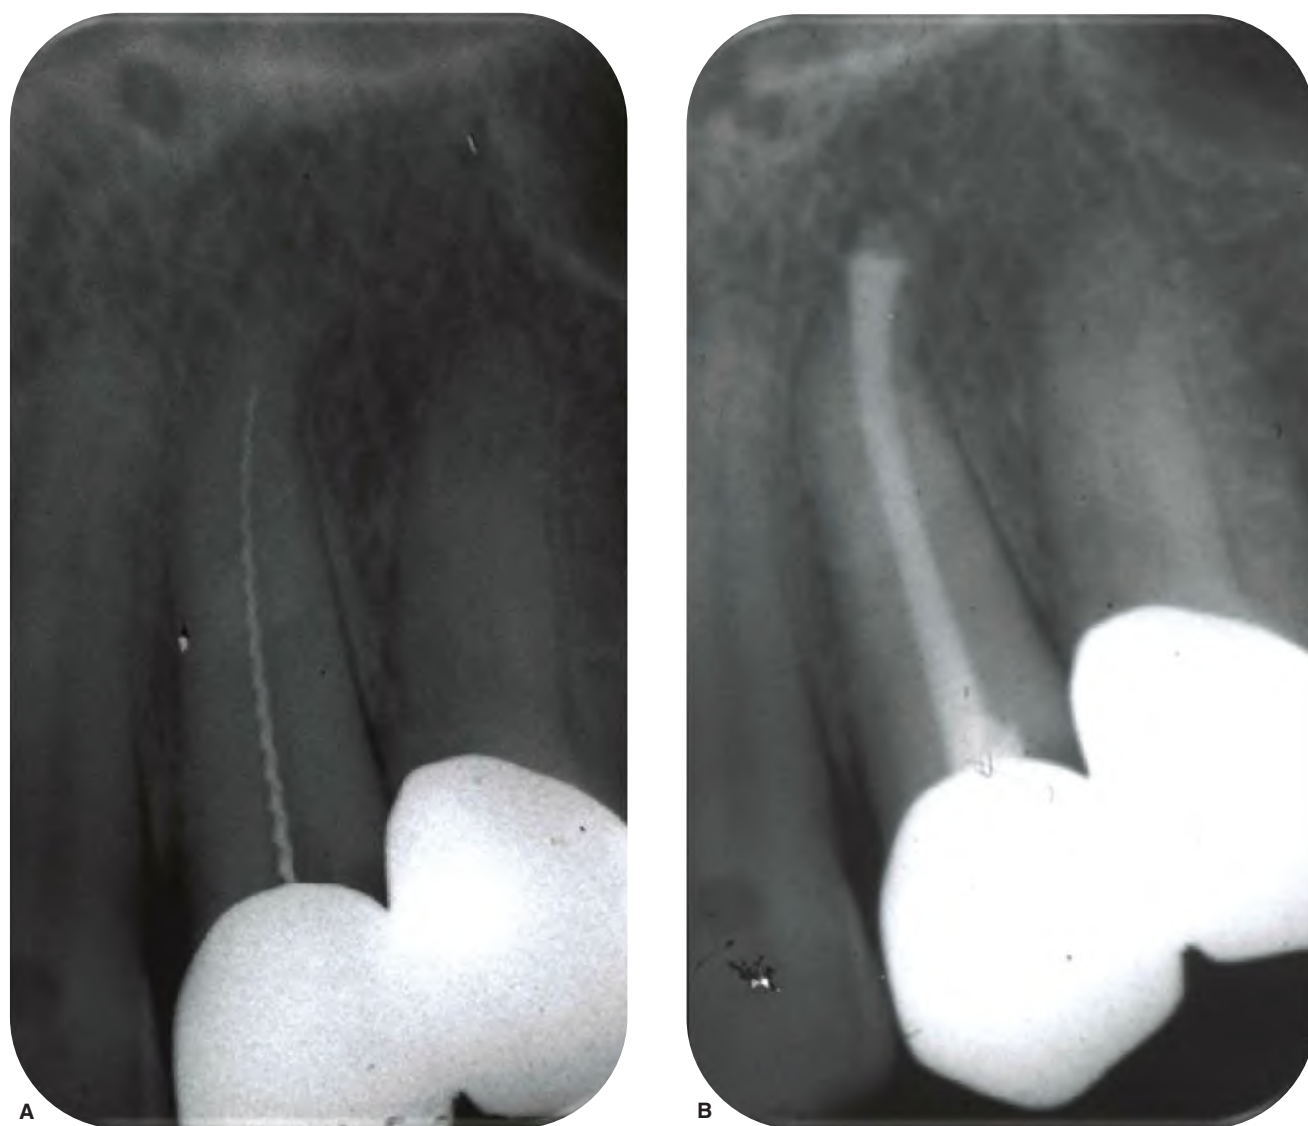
A. Underestimation of the curvature has resulted in severe straightening and apical transportation. B. This is mainly due to improper evaluation of the radiograph and inadequate treatment planning.
